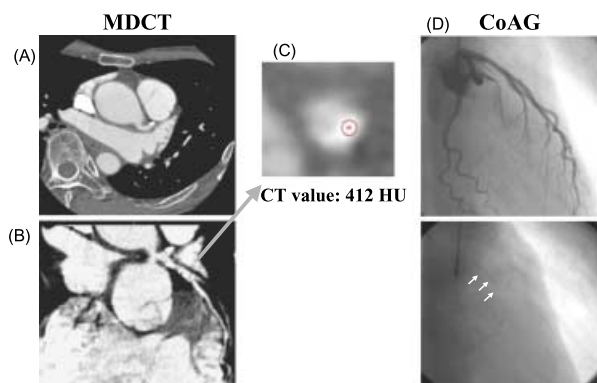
Transverse CT (A), curved MPR (B), cross-sectional MPR (C), and CAG (D) images. (74-year-old men)
